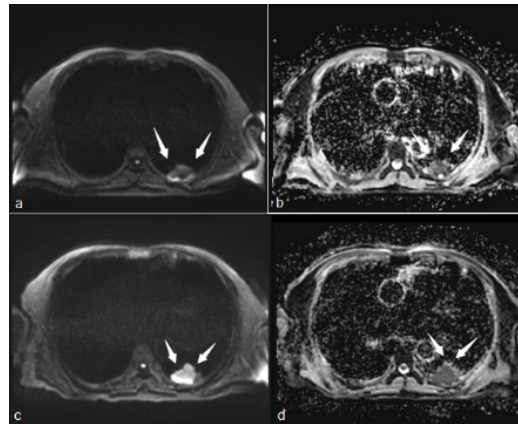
Transverse images in 84-year-old men with adenocarcinoma a) Pre-chemotherapy Transverse diffusion-weighted echo-planar MRI shows mass at the upper left lobe (arrows). b) Pre-chemotherapy ADC map showing that mass is hypointense; ADCmean:0.980x 10⁻³mm²/sec. c) Post-chemotherapy Transverse diffusion-weighted echo-planar MR image shows increase of volume of mass at the upper Left lobe (progression). d) Post-chemotherapy ADC map; ADCmean:0.712x 10⁻³ mm²/sec.
